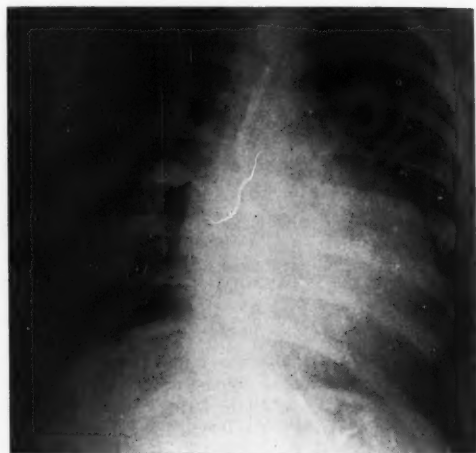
Roentgenogram of the chest in case 2. The heart is enlarged and globular with accentuated vascular markings and tapering narrow base. This appears to be the characteristic configuration of the heart in corrected transposition with ventricular septal defect. A roentgenogram of case 3 was identical in appearance. Case 1 failed to show this configuration, apparently due to displacement of the heart secondary to severe pectus excavatum.
